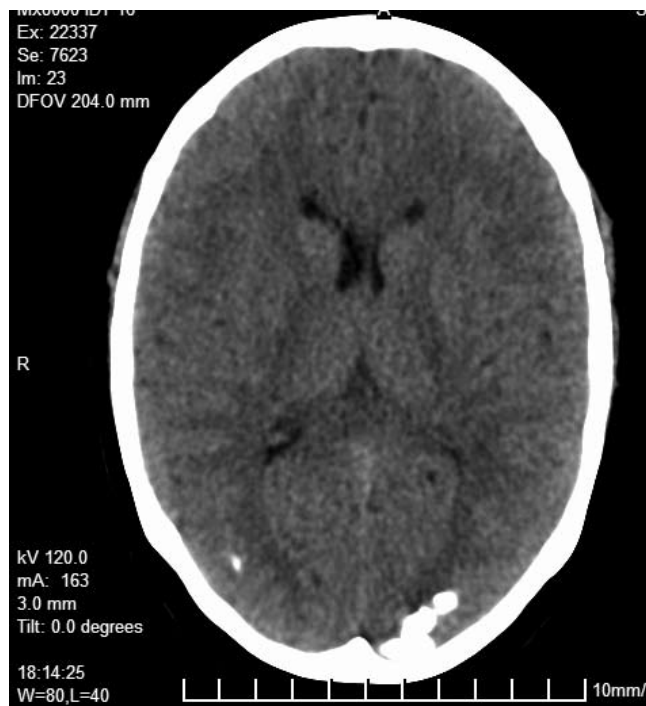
CT Scan showing bilateral calcification in occipital region in a patient with coeliac disease.
